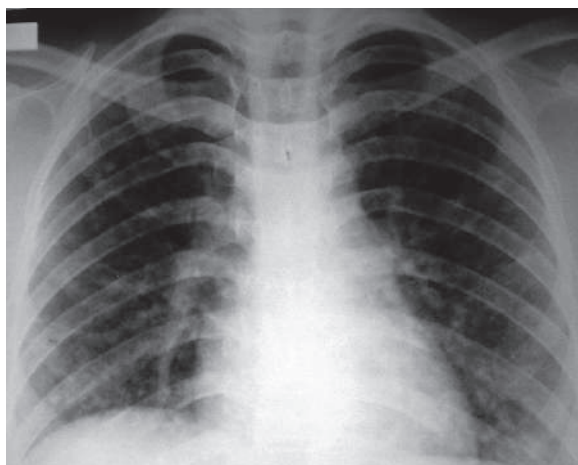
Posteroanterior plain chest radiograph of a patient with Varicella-zoster virus (VZV) pneumonia shows diffuse micronodular interstitial lung pattern bilaterally
